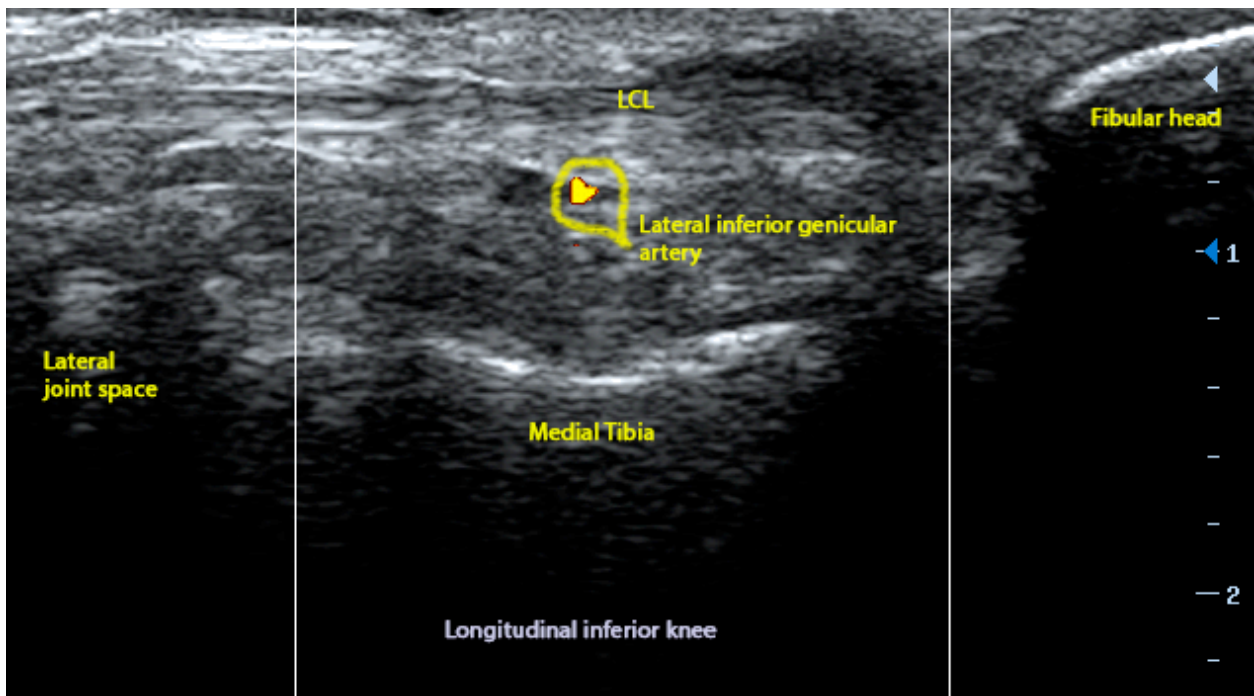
Color Doppler image demonstrating the inferior lateral genicular artery which serves as a landmark for the inferior lateral genicular nerve.
